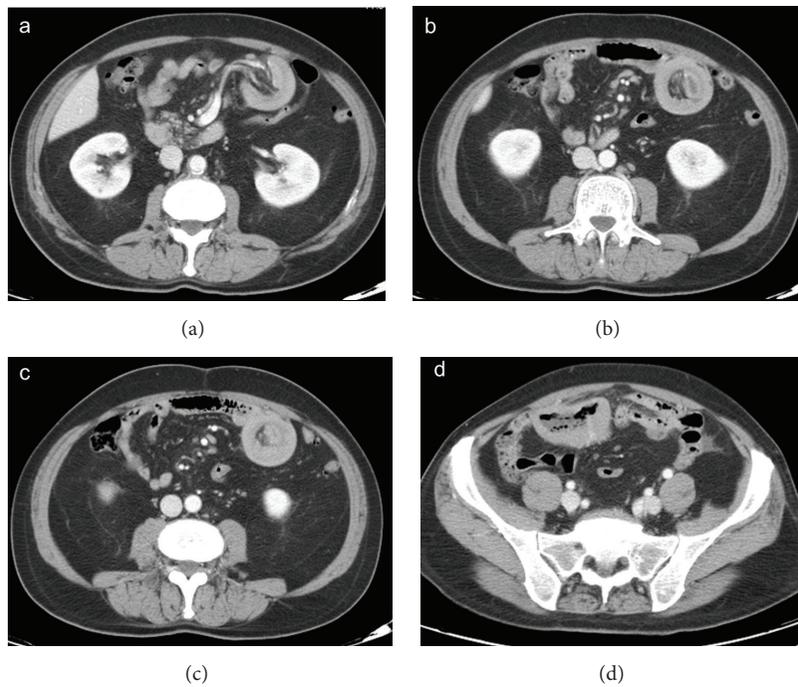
Enteroenteric (ileoileal) intussusception caused by lymphoma. Axial CT images show the typical appearance of small bowel intussusception (a, b, and c). Marked circumferential thickening of the wall of a distal ileum loop (d) is due to lymphoma, which is responsible for intussusception.
